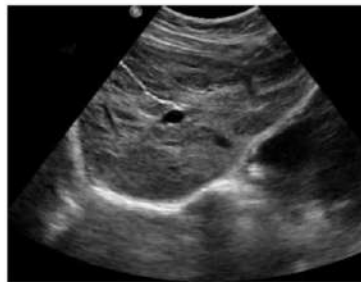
Normal Ultrasound of Liver
